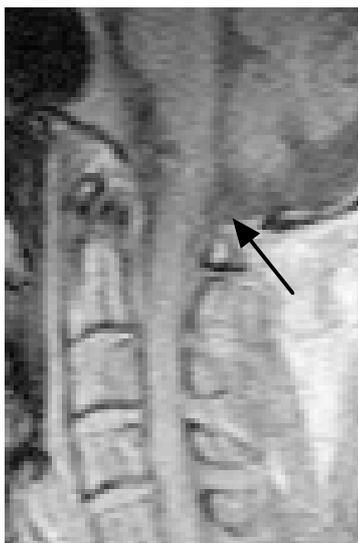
MR imaging (T1 WI) Sagittal slice
